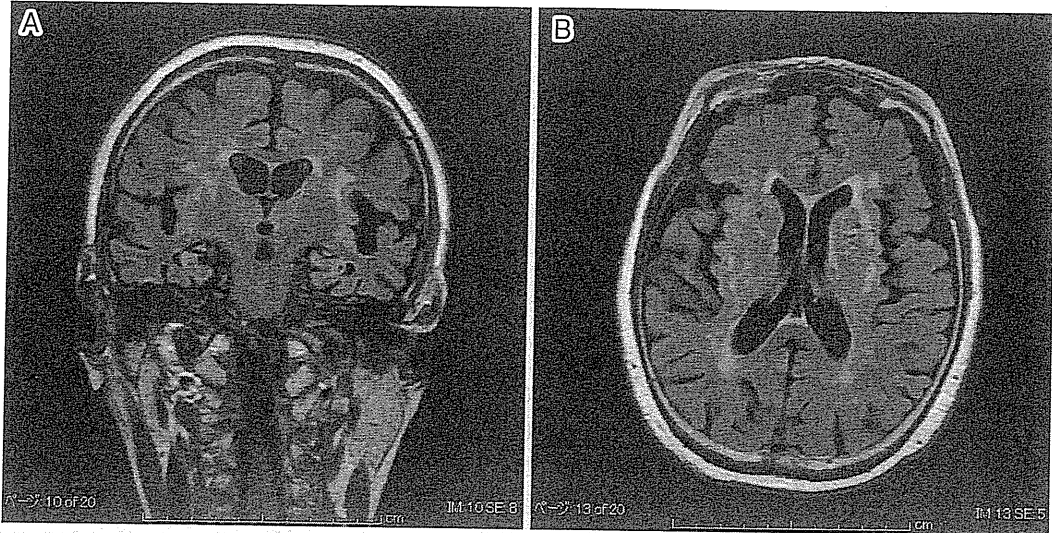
頭部MRI FLAIR A:冠状断像 B:水平断像 前頭葉, 側頭葉皮質に比較的軽度の萎縮を認める。
